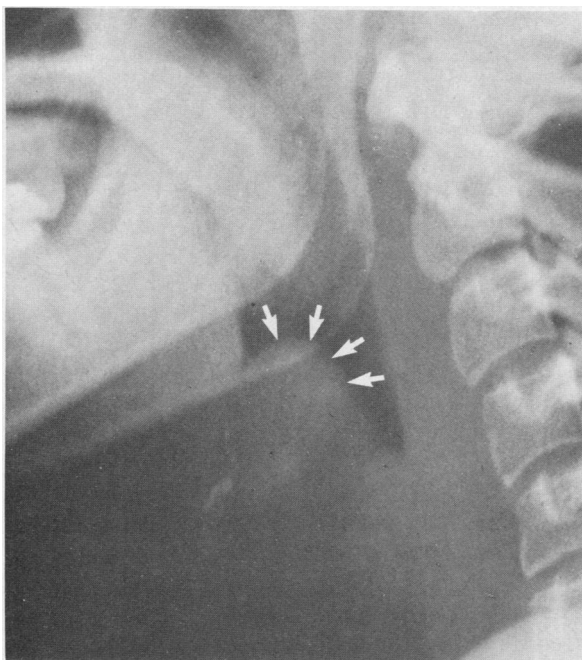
Lateral neck x-ray film showing edematous epiglottitis and effacement of vallecula.
